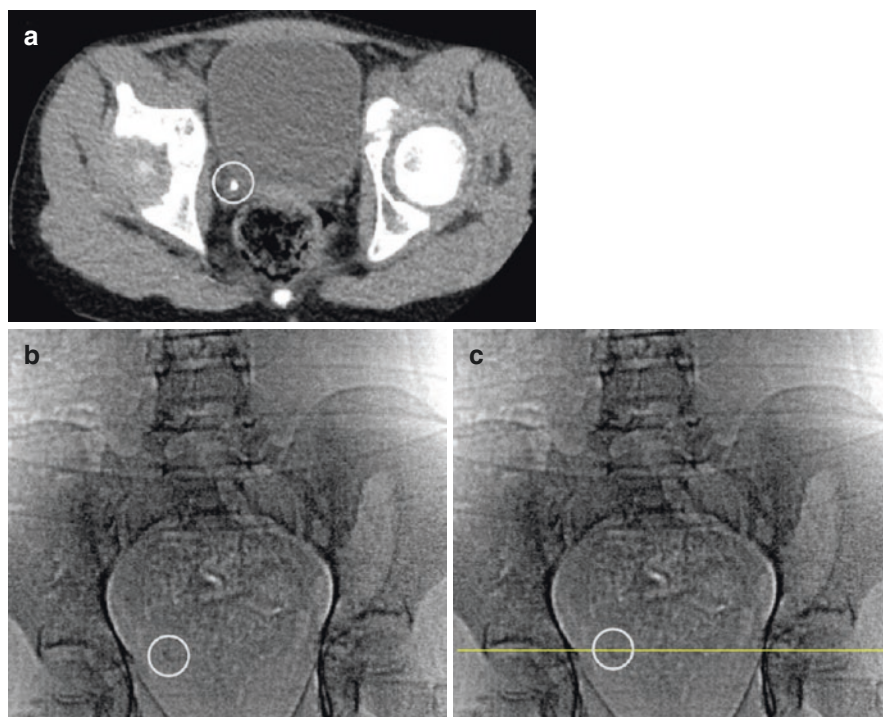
Axial CT (a) and CT scout (b and c) images of a right distal ureteral calculus (gray circle). Note the use of “scout line mode” on the preliminary image (yellow line in “C”) to aid in localizing the calculus in the vertical plane
